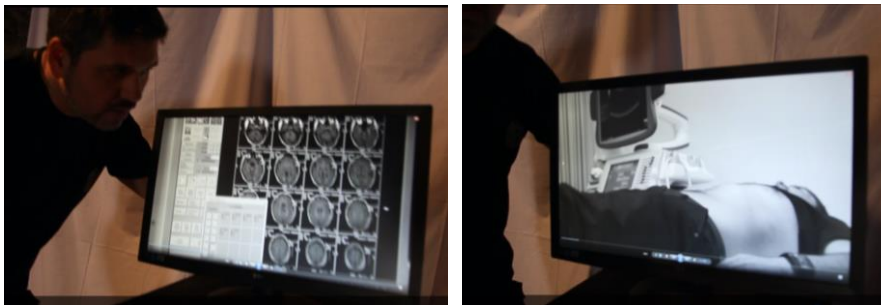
Video which shows author’s MRI examination.
